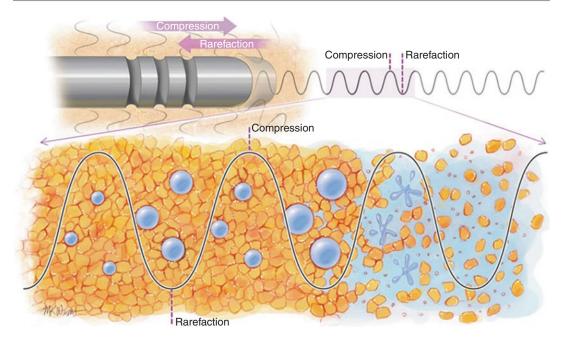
Cavitation effect during ultrasound assisted liposuction. Gaps in the cell membrane get bigger until it collapses
